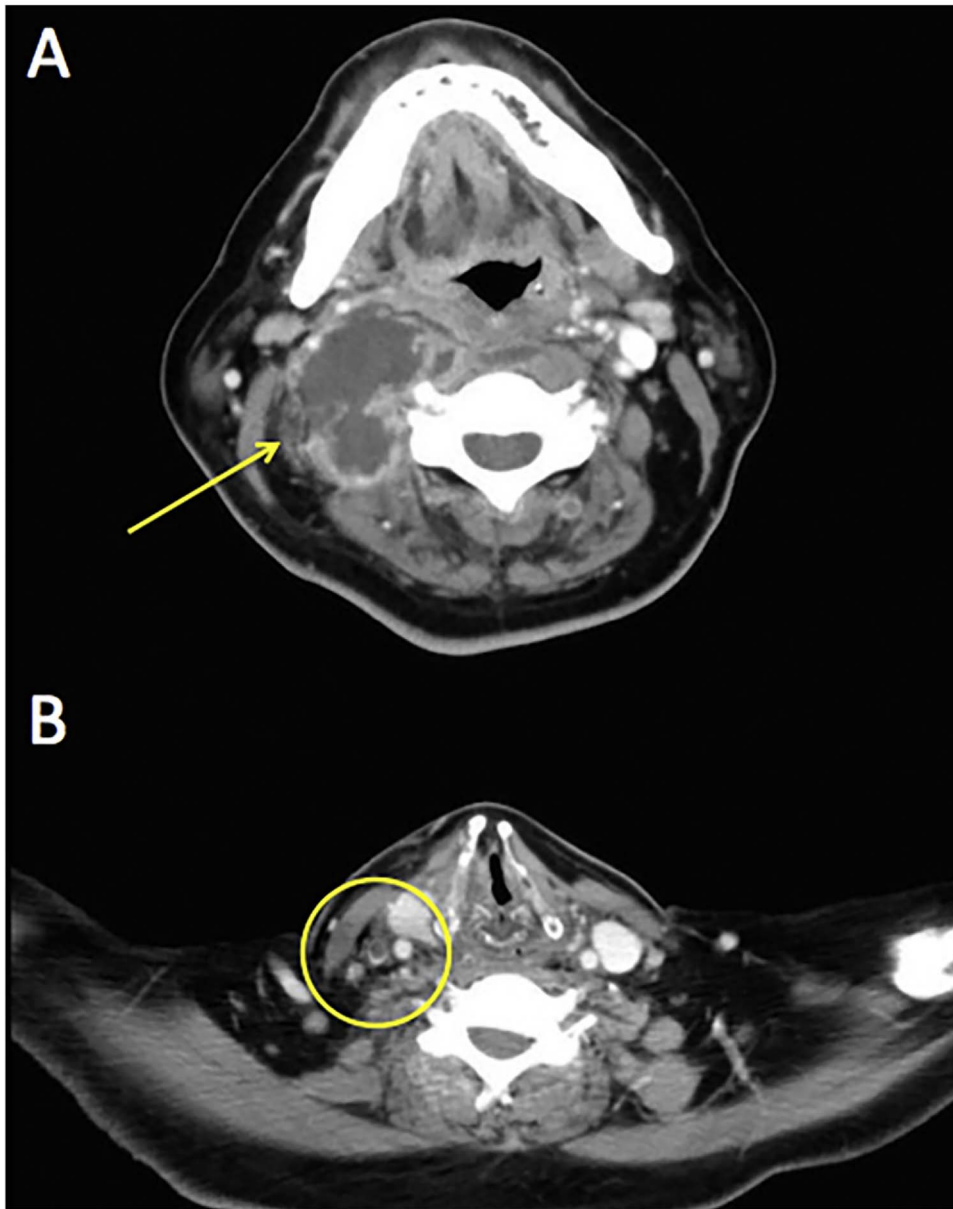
A (above). Neck CT: Large abscess mostly in retropharyngeal space extending from C1 to C6/C7. B (below). Right internal jugular vein thrombosis.
